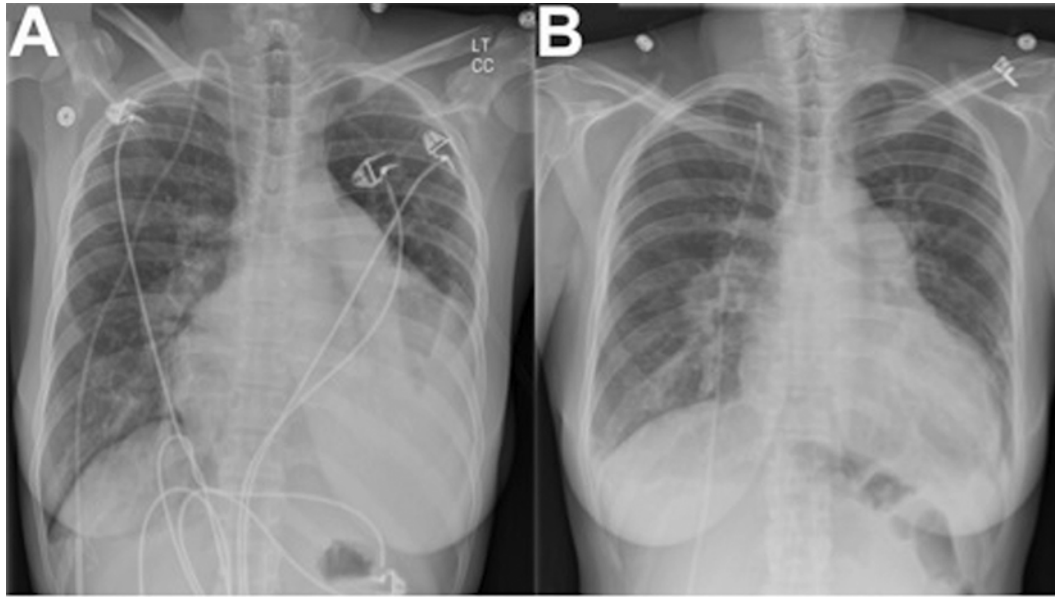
Chest radiographs for a patient with pulmonary arterial hypertension with a large pericardial effusion (A) that resolved after pericardial drainage of 900 mL of pericardial fluid (B). Both radiographs reveal cardiomegaly and enlargement of the pulmonary arteries.
